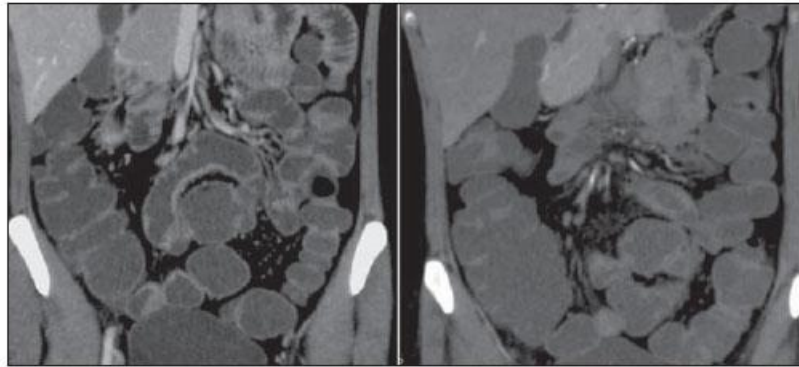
CT enterography, coronal section of a 30-year-old female patient. The study was performed after oral ingestion of non-absorbable neutral contrast medium (polyethylene glycol), demonstrating good distension of different intestinal segments, from the jejunum to the ileum, with appropriate contrast-enhancement of the intestinal walls.
